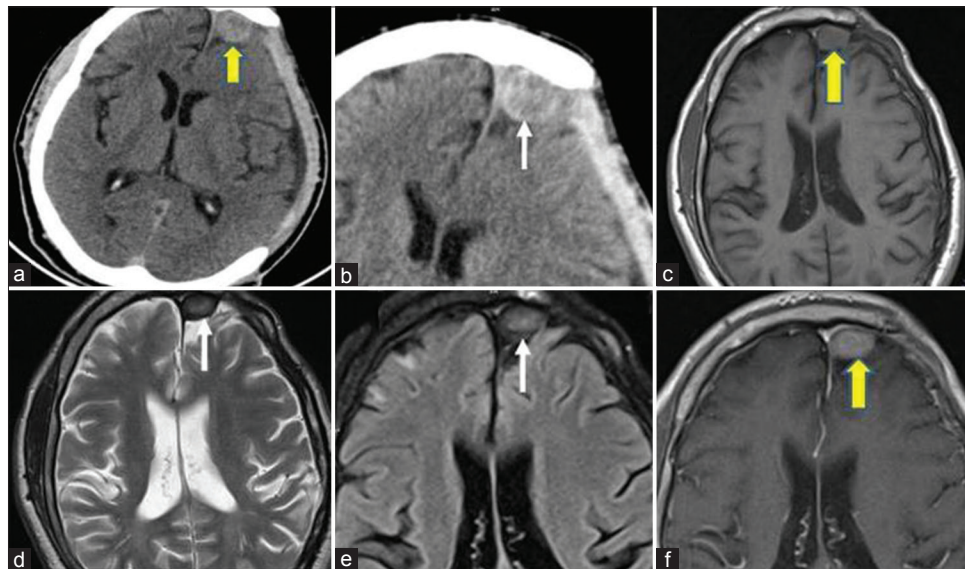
Case 2: Decompressive craniectomy was done for subdural hematoma involving left parietal lobe. Patient complained of memory loss for which computerized tomography followed by Magnetic resonance imaging was done. (a) Noncontrast computerized tomography shows a rounded hyperdense lesion (yellow arrow) in the left frontal location. (b) Contrast-enhanced computerized tomography shows prominent peripheral enhancement. (c) Axial T1-weighted image of the brain shows an iso- to hypo-intense lesion in the left frontal lobe (yellow arrow). (d and e) T2-weighted and fluid-attenuated inversion-recovery (FLAIR) images showing a hyper- to iso-intense lesion with a surrounding hypointense rim (thin white arrow). (f) Postgadolinium image shows diffuse nodular enhancement (yellow arrow)
